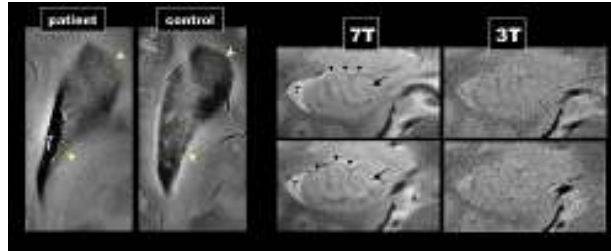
High resolution imaging using 7 tesla MRI Images on the left show atrophy and iron accumulation within the right basal ganglia of a patient with an atypical movement disorder compared to a normal control subject Images on the right compares the right hippocampus of a patient with epilepsy acquired using 7 tesla (left) and 3 tesla (right) MRI
